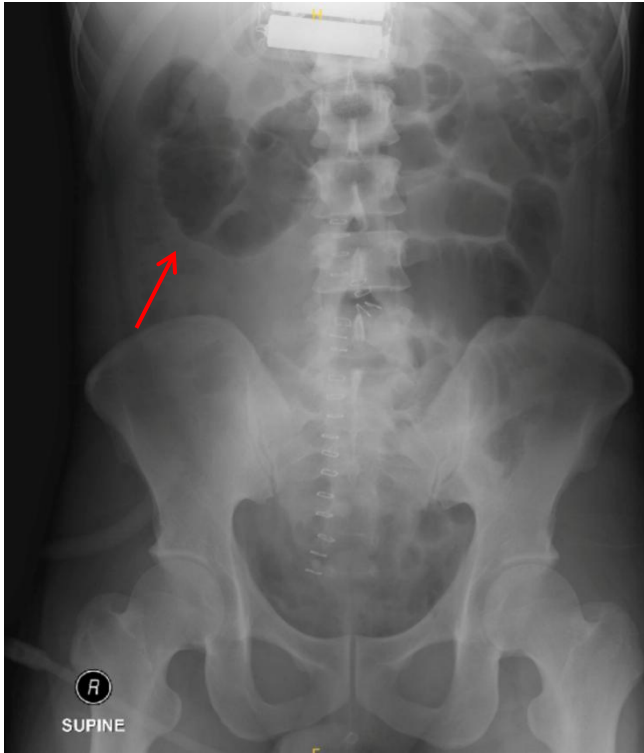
Abdominal X-ray revealed a gas filled segment of bowel at the right upper part of abdomen. (Red arrow)
